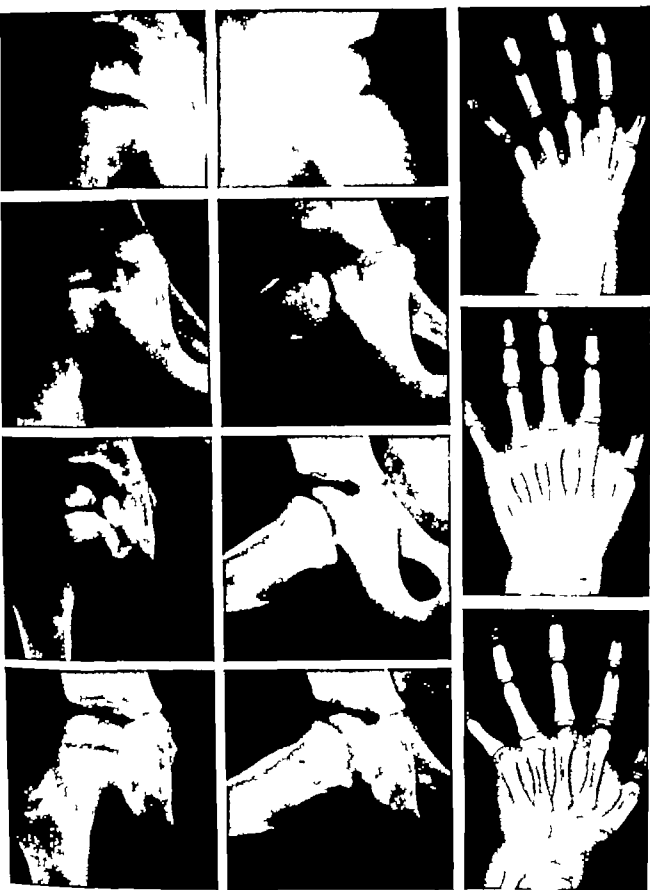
Female 4339 Roentgen progress of LCPS and bone age maturation plates. A typical return to mean determinations Aureomycin was continued until mean bone age was achieved. There will be an excellent end-result, Type 1 spheroidal.¹²
